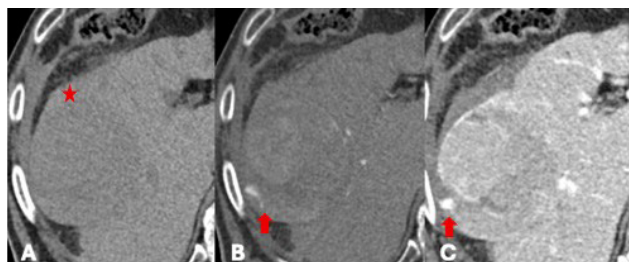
Computed tomography scan before (A) and after intravenous administration of iodinated contrast in arterial (B) and portal venous (C) opacification phases.
